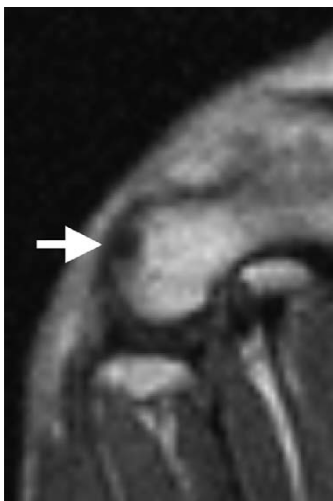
Subchondral fracture in the lateral aspect of the trochlea on T1-weighted image, 4 hours after impact (same knee as in Figure 1).
